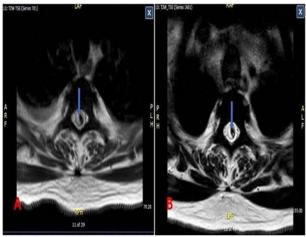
Axial T2 spinal MRI images show hypo intensity suggestive of intraparenchymal haemorrhage on left side with surrounding hyper intensity suggestive of cord oedema indicated by blue vertical arrows (Figs 4A & 4B).
